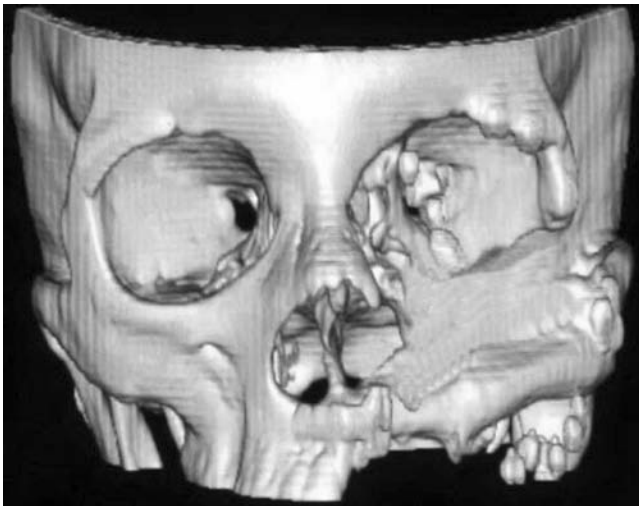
Three-dimensional CT scan demonstrating the scapular bone with three-point fixation. The orbit and nasal cavities have been contoured.
